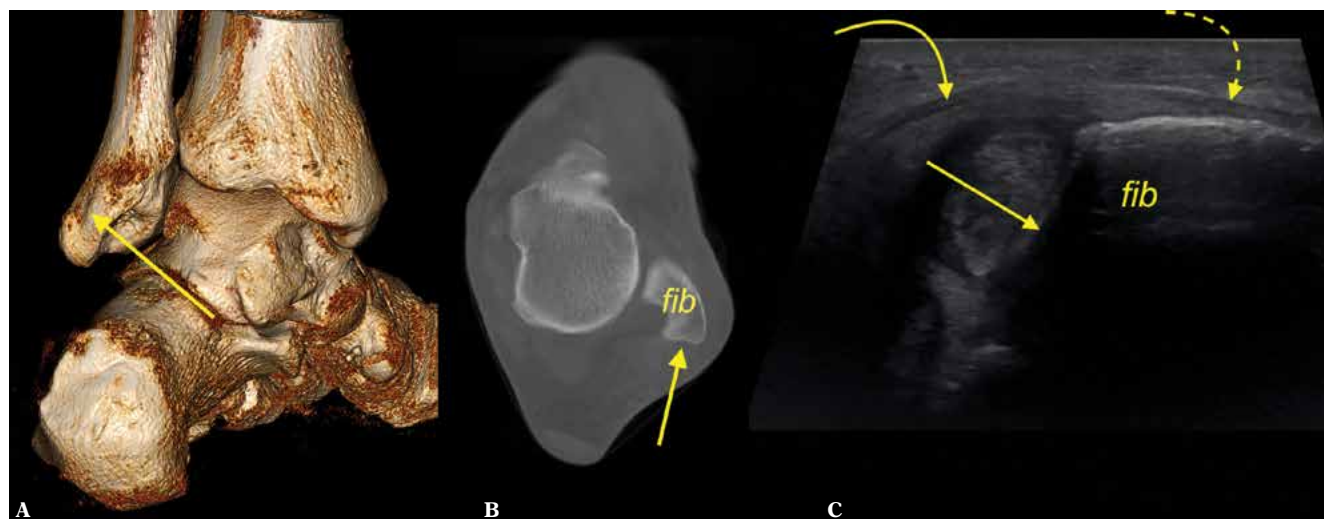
The most common variant of the retromalleolar fibular groove, convex (straight arrow). A 39-year-old patient with a suspicion of rheumatoid arthritis. A, B. cone-beam computed tomography (A. 3D posterior medial view, B. transverse section), C. transverse ultrasound section. SPR (curved arrow) was connected (dashed curved arrow) to IER (not shown). Fib – the lateral malleolus
